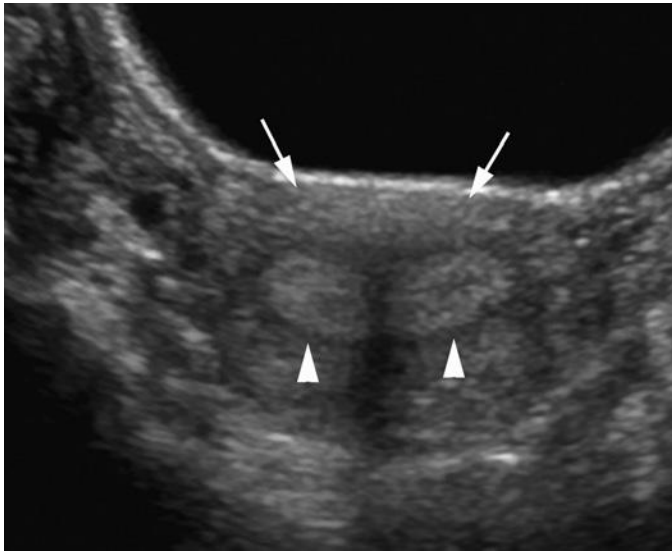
Septate uterus. Transverse ultrasound image of the uterus in a 15-year-old girl with dysmenorrhea reveals two distinct endometrial cavities (*arrowheads*). The external myometrial fundal contour is normal (*arrows*).
